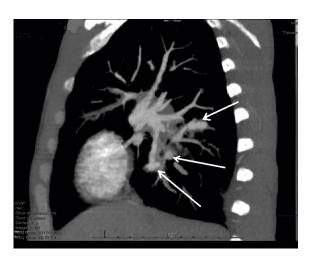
A sagittal reconstruction of the chest CT angiogram showing the right pulmonary vessels with multiple pulmonary artery aneurysms (arrows).
